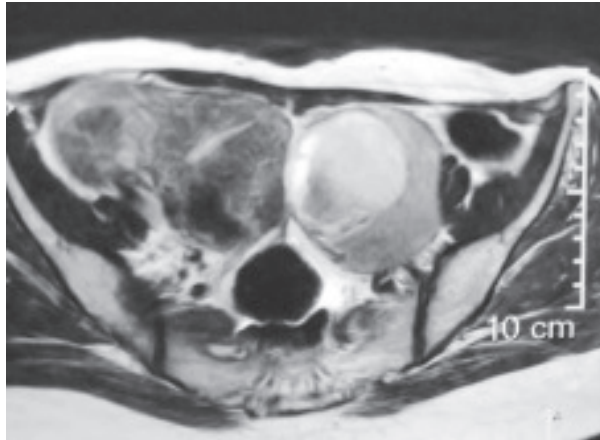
Case 4, MRI- Uterus is bulky, measures 12 x 6.5 x 5.7 cms. A large subserosal fibroid measuring 5.5 x 4.9cms is seen in fundal region. Multiple smaller intramural and subserosal fibroids are seen in body region in anterior and posterior wall, largest measuring 3 x 2.2 cms in posterior wall. Complex tubo-ovarian cystic lesions are seen in bilateral adnexa measuring approximately 4.8x3.7 cms on right side and 7.2x6 cms on left side. Dilated fallopian tubes are seen at medial aspect of lesions (Left>Right). Multiple thin septations are seen within them. Chronic blood products appearing heterogeneously hyperintense on T_1 and T_2 and FAT SAT with shedding effect on T_2W_1 . Bilateral ovaries are not separately visualized.
